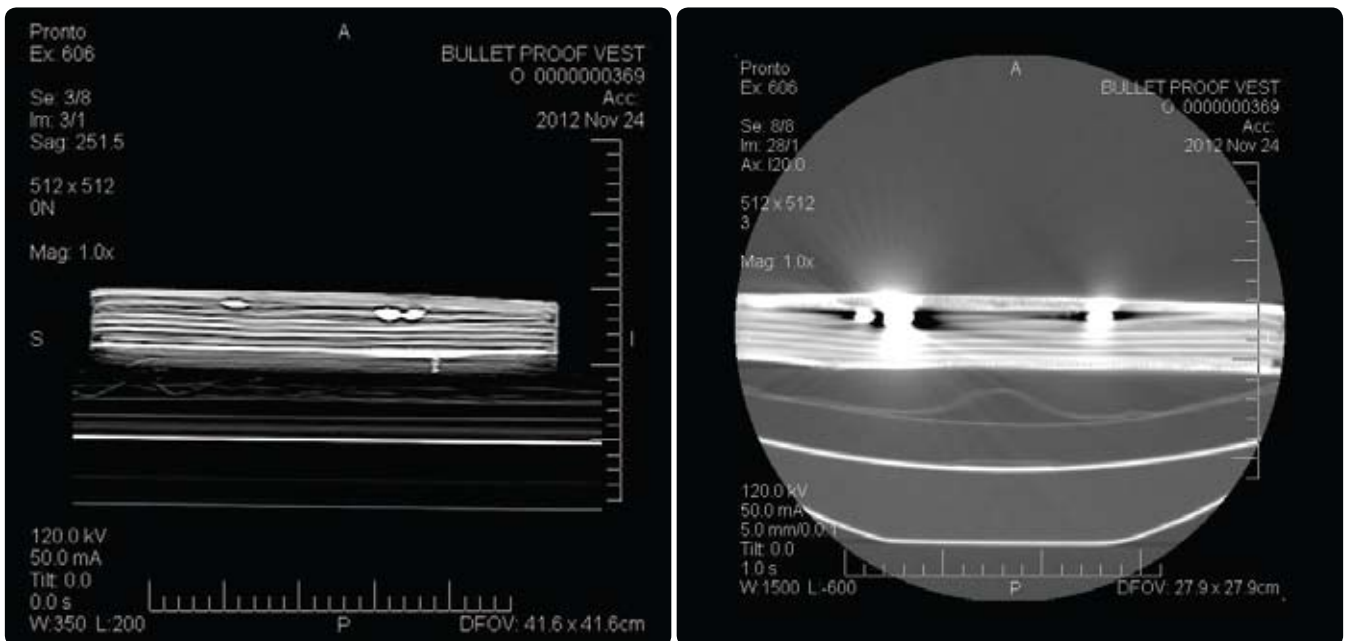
Computed Tomographic images of bullet proof vests
